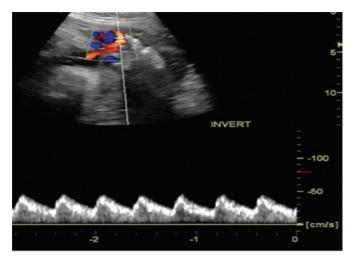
Obstetric Doppler showing a normal umbilical artery. Source: Clínica Fértile
